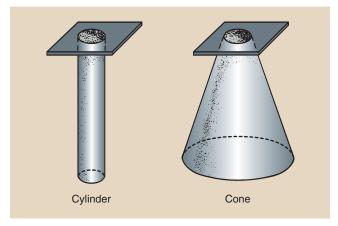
Radiographic cones and cylinders produce restricted useful x-ray beams of circular shape.
